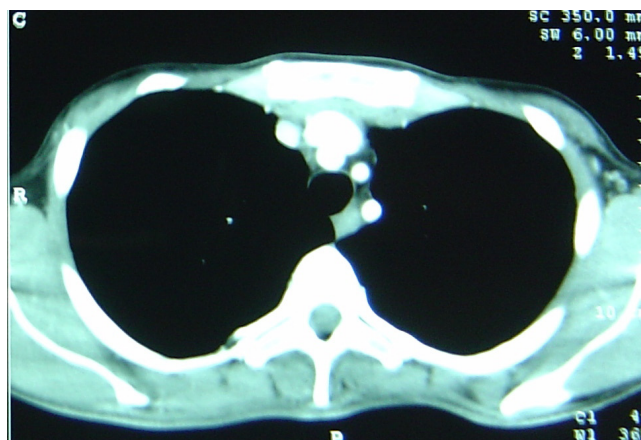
Absence of multiple muscles (CT)
